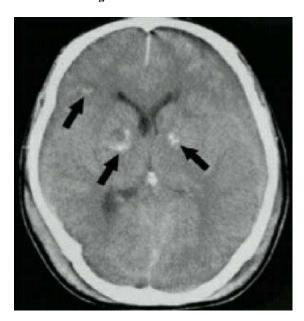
Subcortical and thalamic lesions in CT
